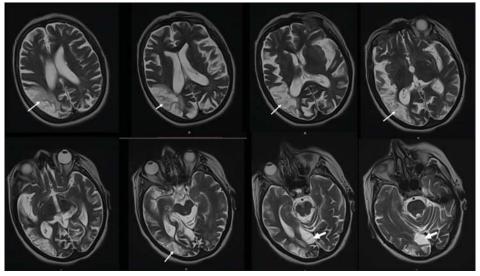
T2-weighted magnetic resonance imaging sequences performed 2 months after stroke, showing ischemic lesion in the right temporoparietal lobe (arrows) and sequela lesion in the right occipital lobe (thick arrows)
